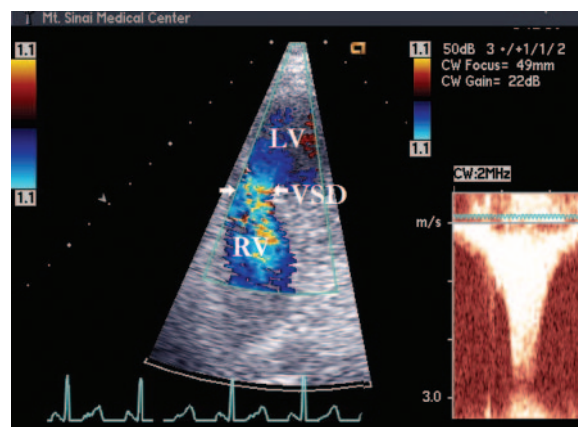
Two-dimensional echocardiography. Closeup of ventricular septum in apical 4-chamber view (left) demonstrates turbulent systolic color flow Doppler across large VSD. Continuous wave Doppler (right) demonstrates systolic flow across VSD.
